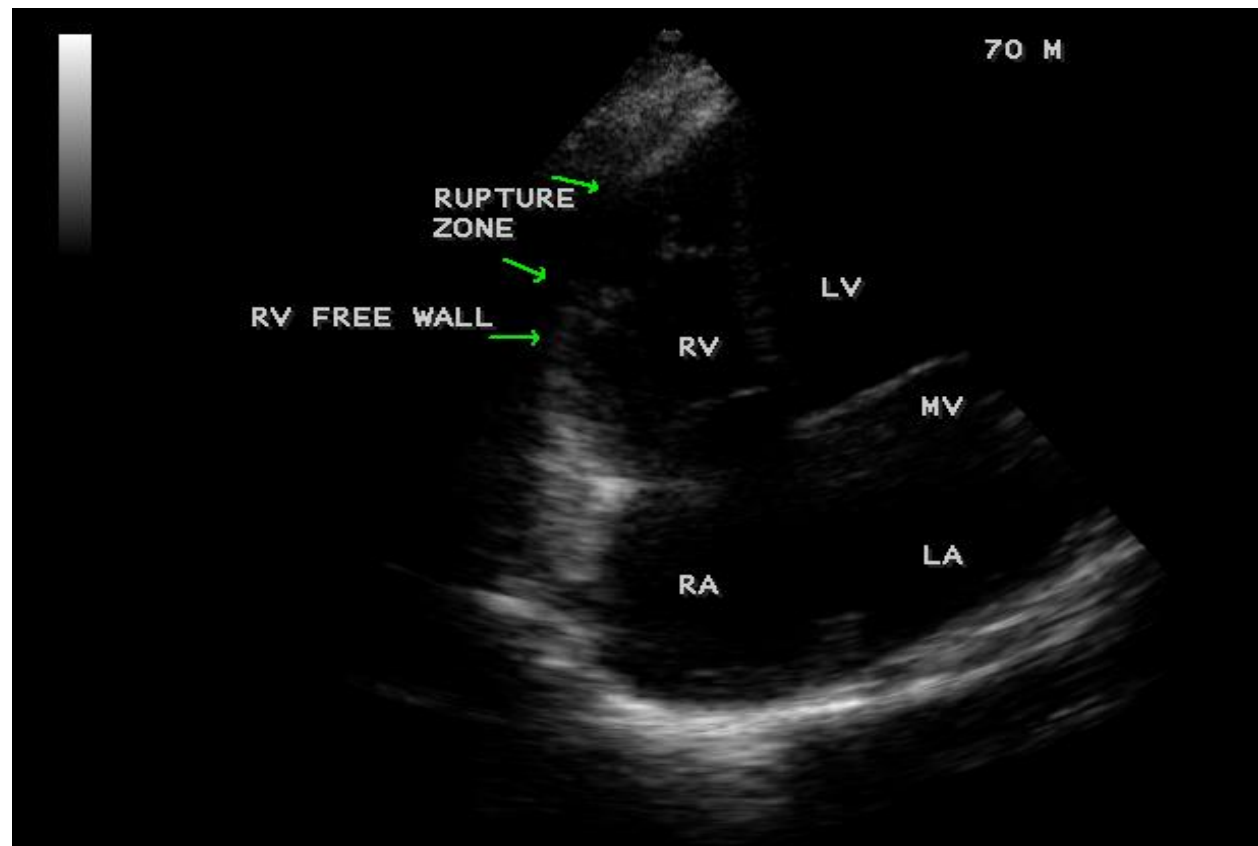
2D echocardiographic imaging showing the large RV free wall rupture in a 70-year old male with right ventricular infarction in apical four chamber view.
